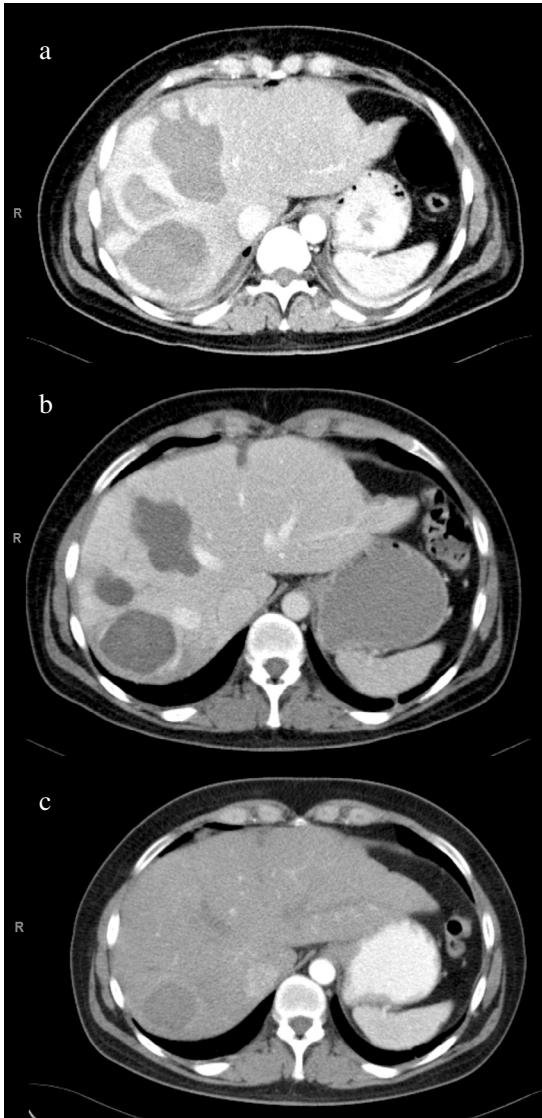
CT image 3 days (a), 2 months (b) and 16 months (c) after RFA. There is no enhancing tissue observed around the zone of thermal ablation, indicating adequate treatment effect.
